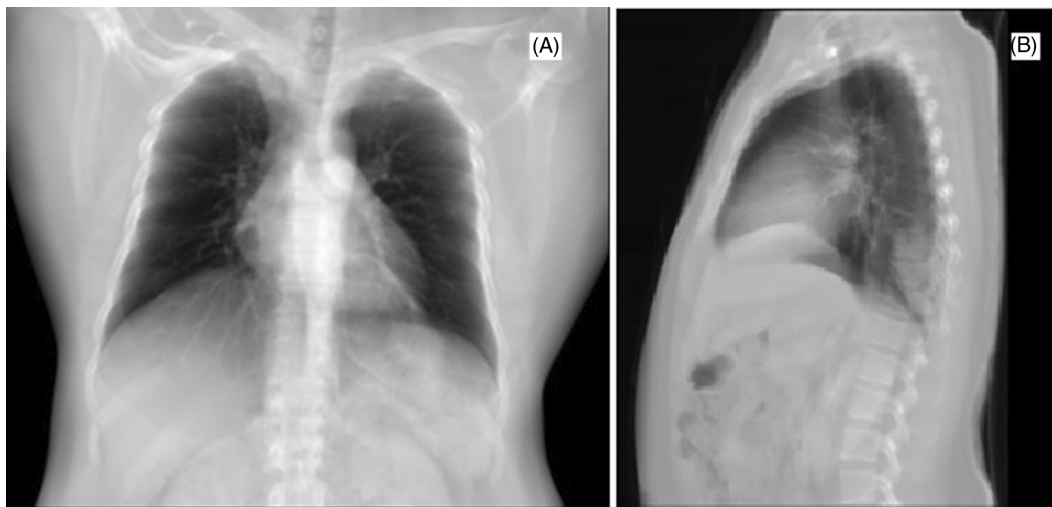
(A) Chest radiograph showing left lower zone cavity with fluid level and surrounding consolidation. (B) Lateral chest x-ray showing posterior basal segment air fluid level.
